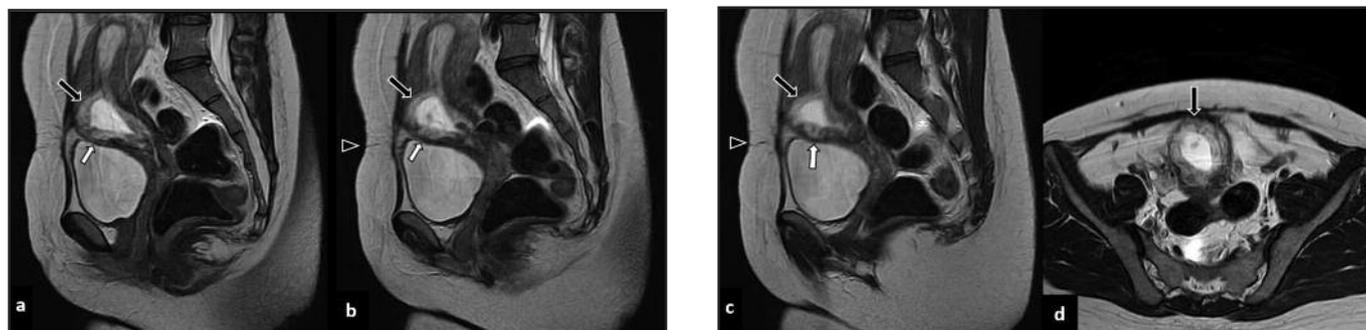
Sagittal (a-c) and Axial (d) T2-weighted MR images showed gestational sac (black arrow, a-d) within anterior lower uterine segment, with adjacent myometrial thinning (white arrow, a-c). The pregnancy is centered at the level of previous caesarean section scar (arrowhead, b,c).
